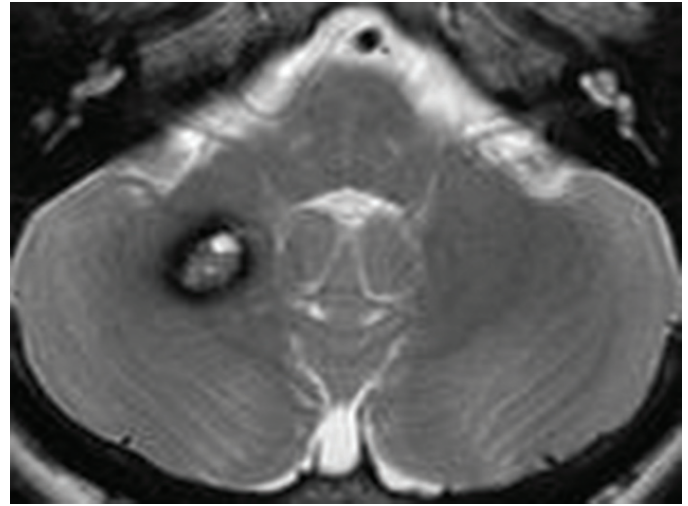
The axial T2-weighted image shows the lesion in the right cerebellar hemisphere which corresponds to the cavernous angioma
